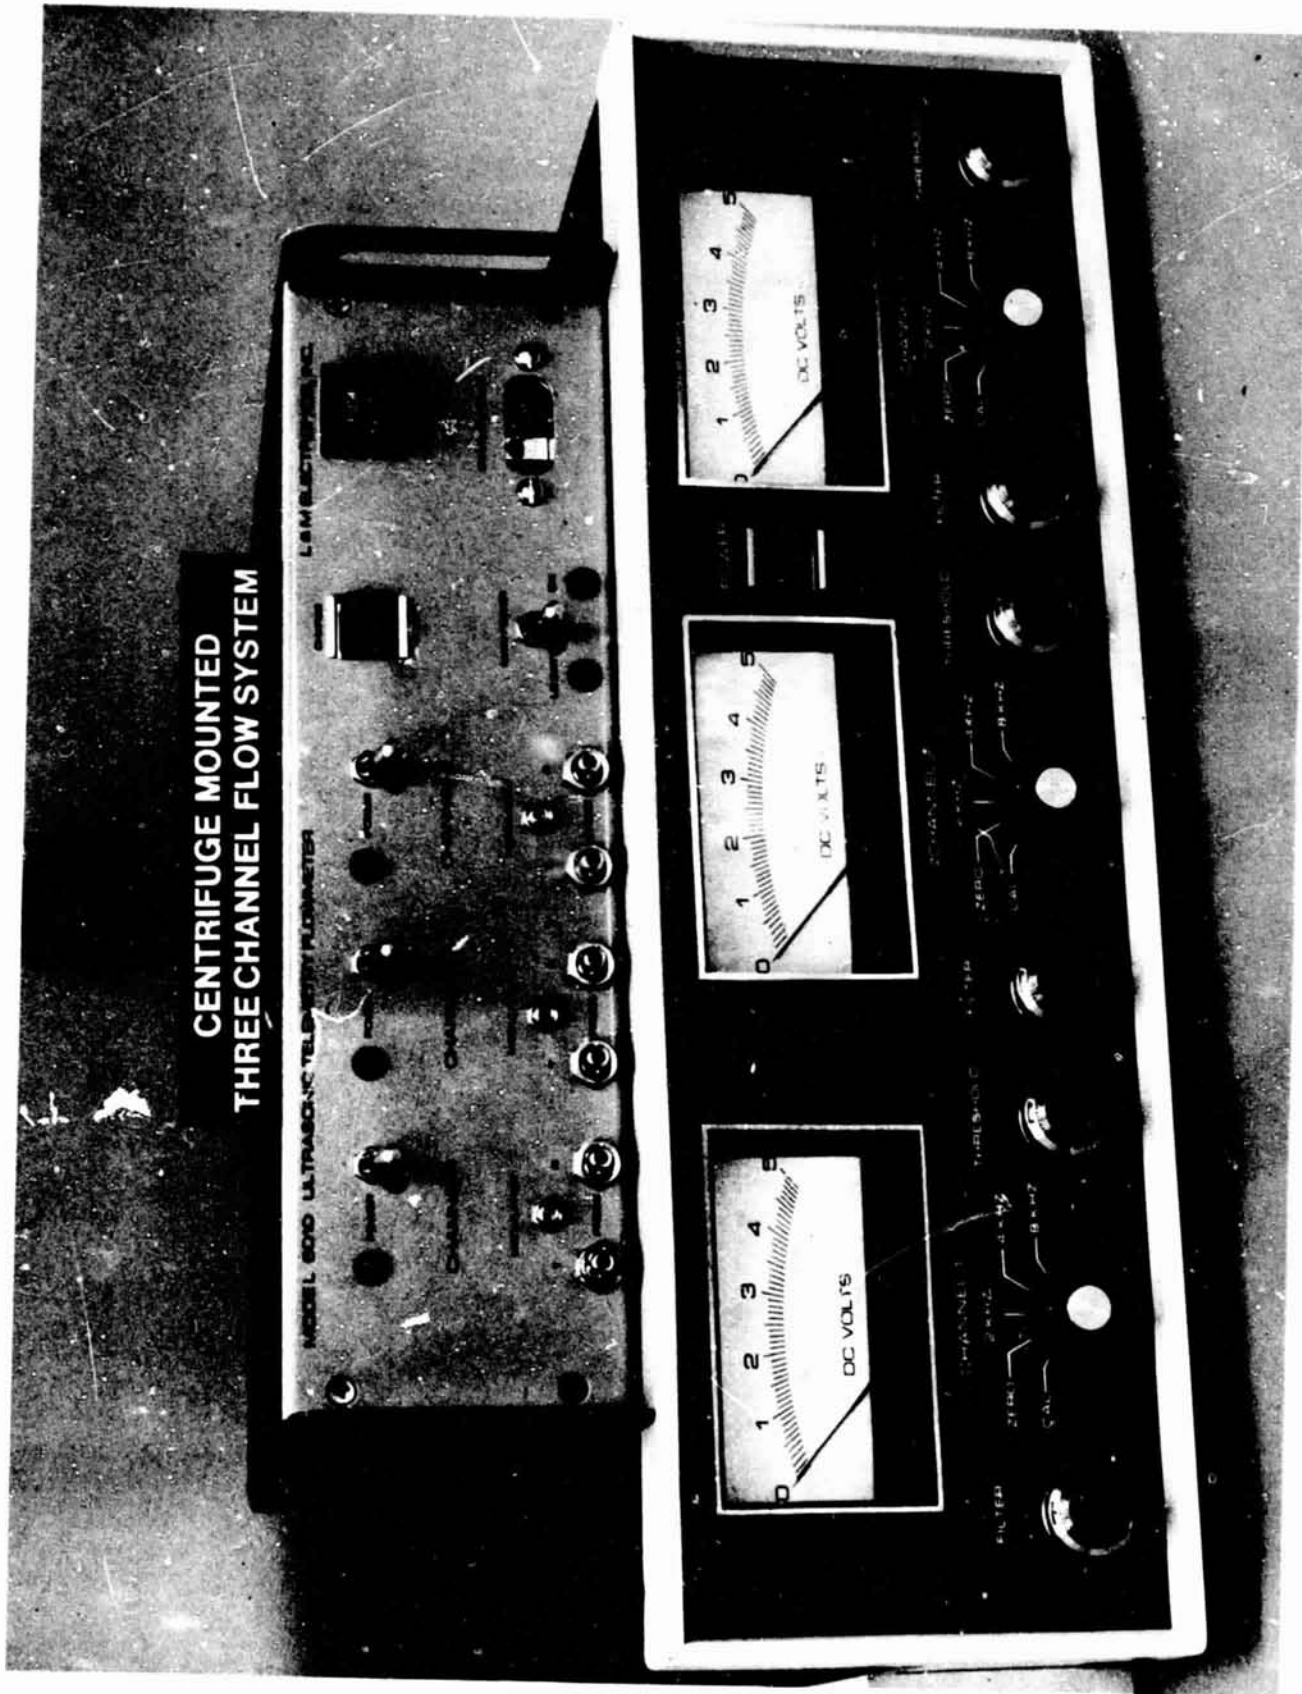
Ames three channel hardwire telemetry Doppler flowmeter.
